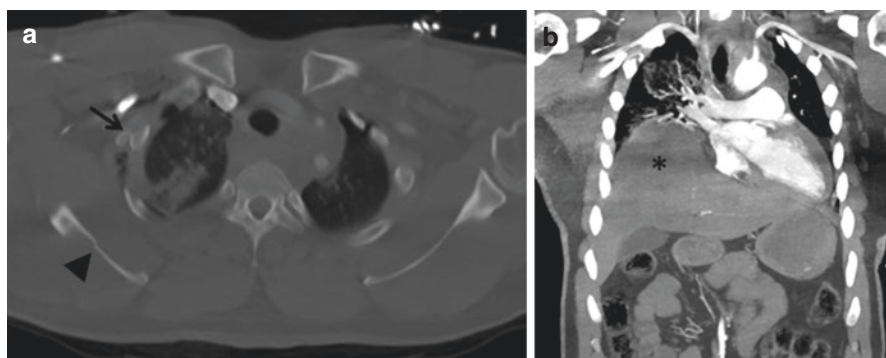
Selected axial (a) and coronal (b) cuts from a chest CT of a patient who presented after a significant blunt force trauma. Seen are multiple rib fractures (*black arrow*), a right scapular fracture (*black arrowhead*) and associated pulmonary contusion, subcutaneous emphysema, and a right diaphragmatic rupture with the liver herniated into the right chest
